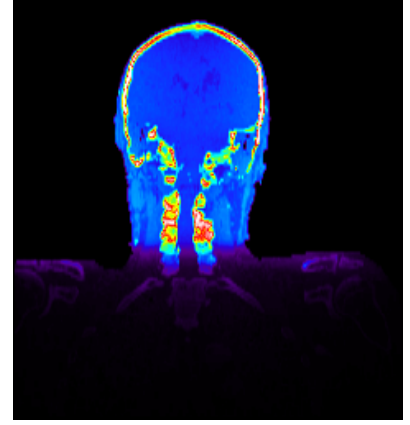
Isocentric slices for Pat. C for a cone beam CT acquisition (360° tube rotation). The slice positions are marked in the CT-slices shown in (n) - (p).
